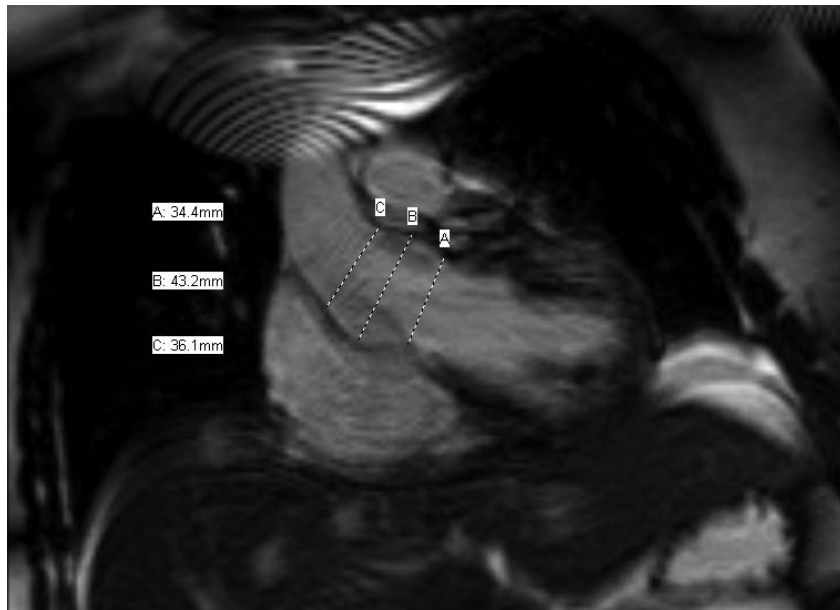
Normal aortic valve. Annotated. Heart. MRI. Steady-state free precession. Coronal plane. Level through the aortic root.
